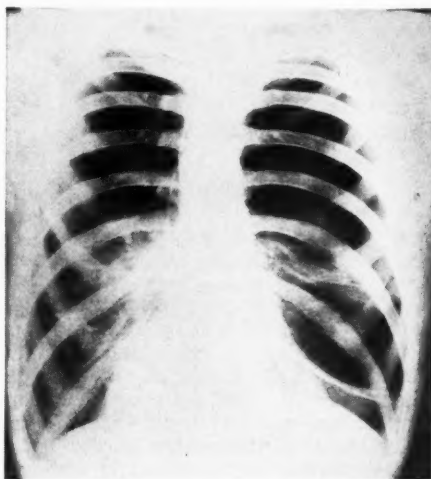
Roentgenogram of chest.
